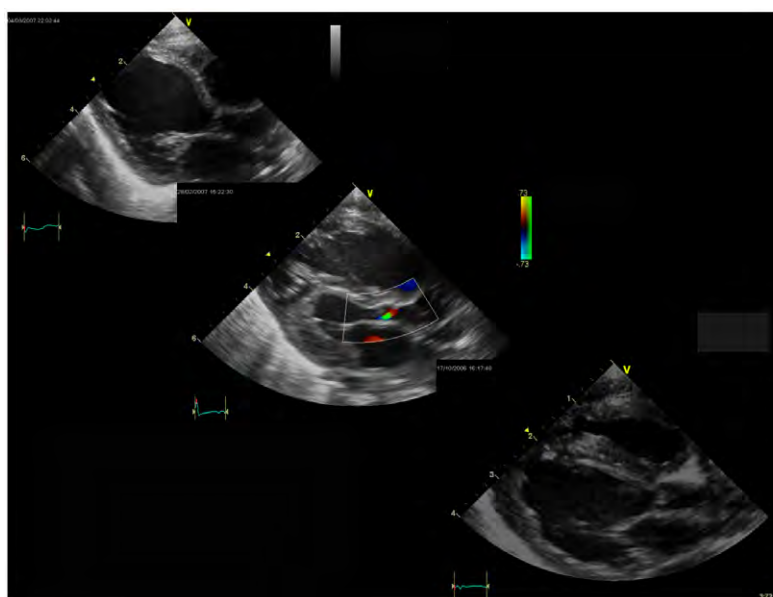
More sophisticated 2D Echo images with colour Doppler from 1980s
